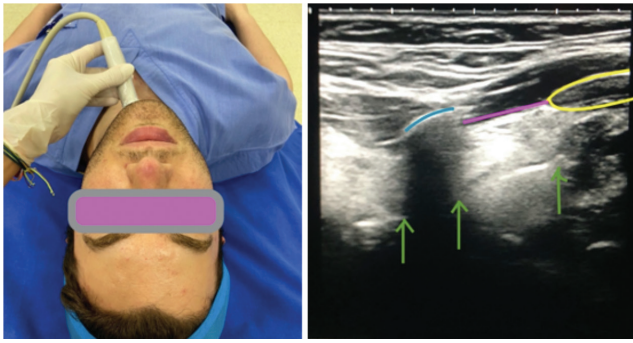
Epiglottis depth at 3 levels with ultrasound
